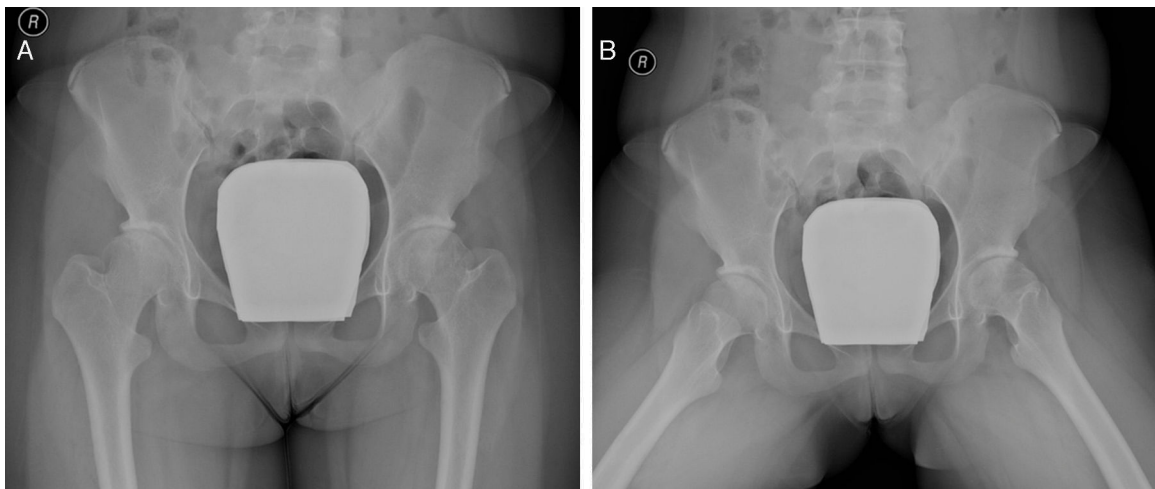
Anteroposterior (Panel A) and frog-leg lateral (Panel B) radiographs of the pelvis showing normal left hip joint space with discrete acetabular sclerosis.
